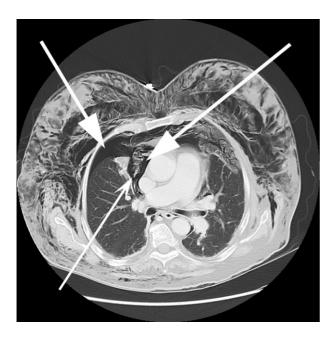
Axial CT scan of the chest demonstrating pneumomediastinum and a right pneumothorax (large arrows). Note communication between both (thin arrow).
